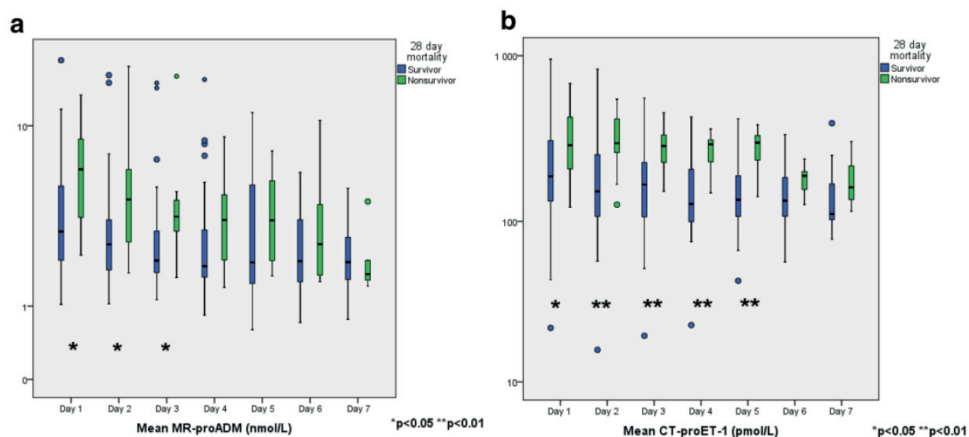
Temporal development of MR-proADM (a) and CT-proET-1 (b) during the first 7 days of ICU admission among septic shock 28-day survivors and non-survivors
